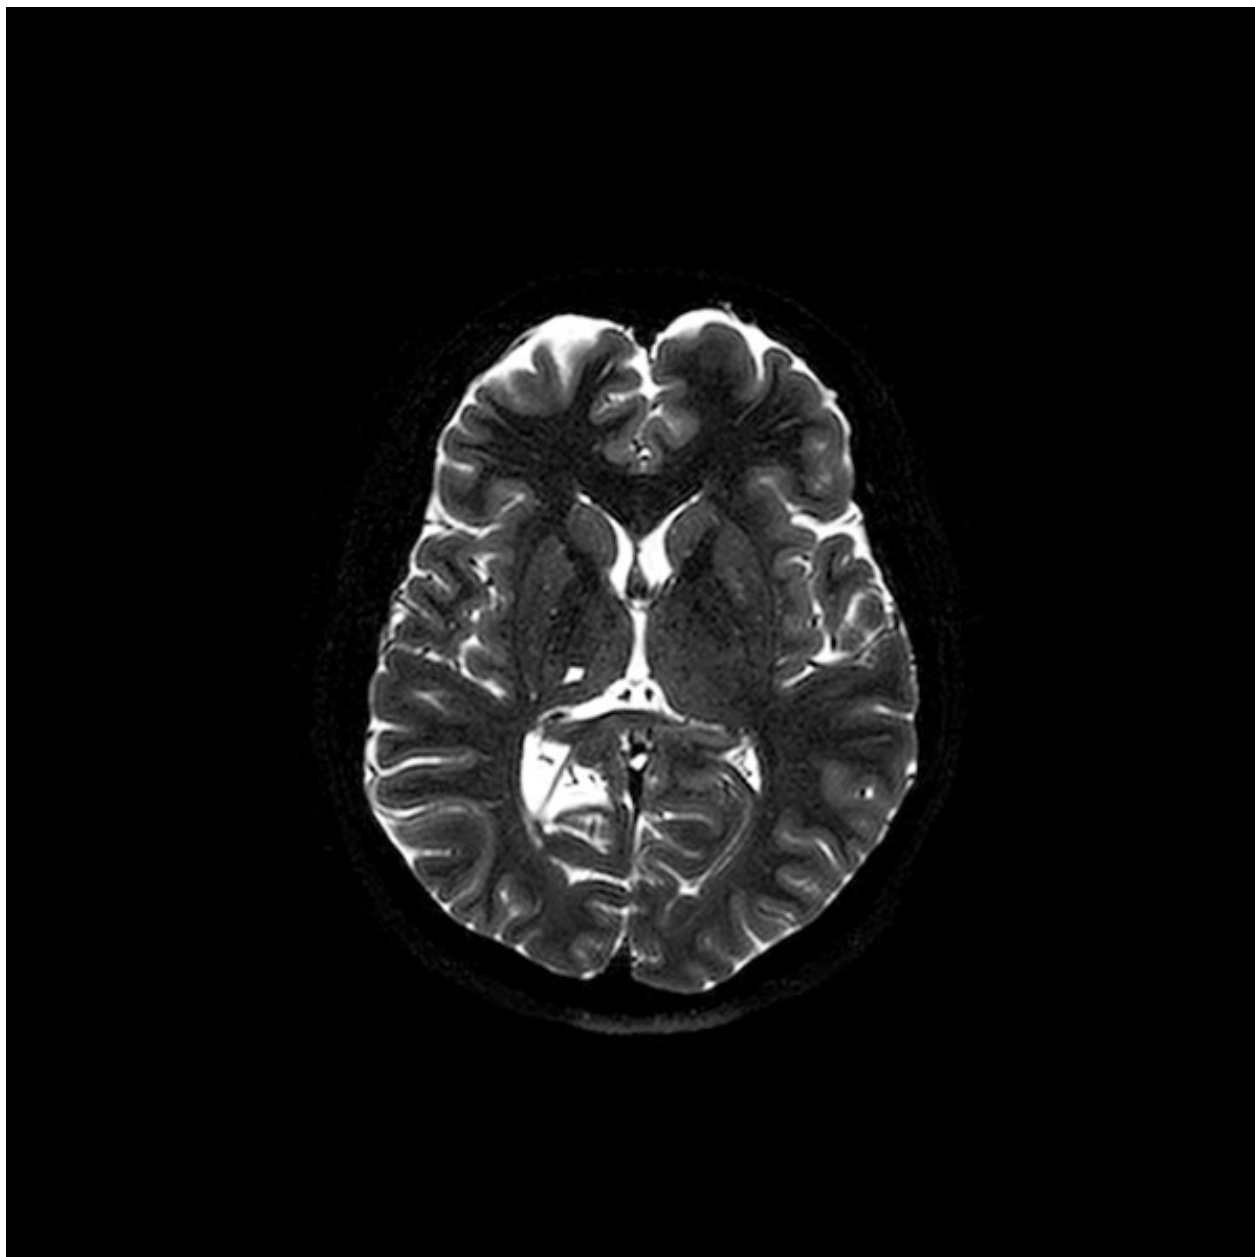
Magnetic resonance image, T2-weighted sequence showing right thalamic lacunar cerebral infarction.
